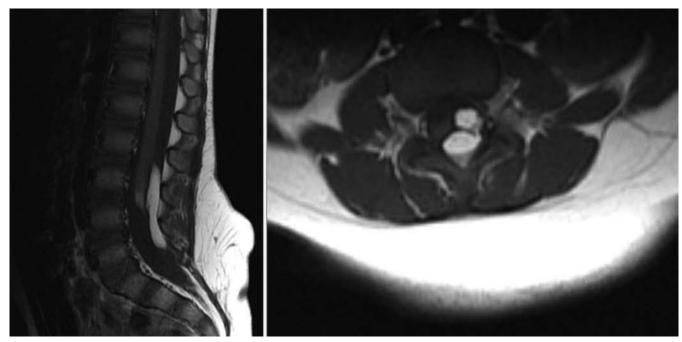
Magnetic resonance imaging with T1-weighted sagittal (A) and axial (B) sequences of 2-year-old with lipomyelomeningocele. The conus medullaris terminates at L-4 and is tethered by an intraspinal lipoma measuring 4.5 cm in length. The intradural lipoma is connected with abnormal extradural fat. There is also extensive, abnormal subcutaneous fat at the gluteal cleft.
